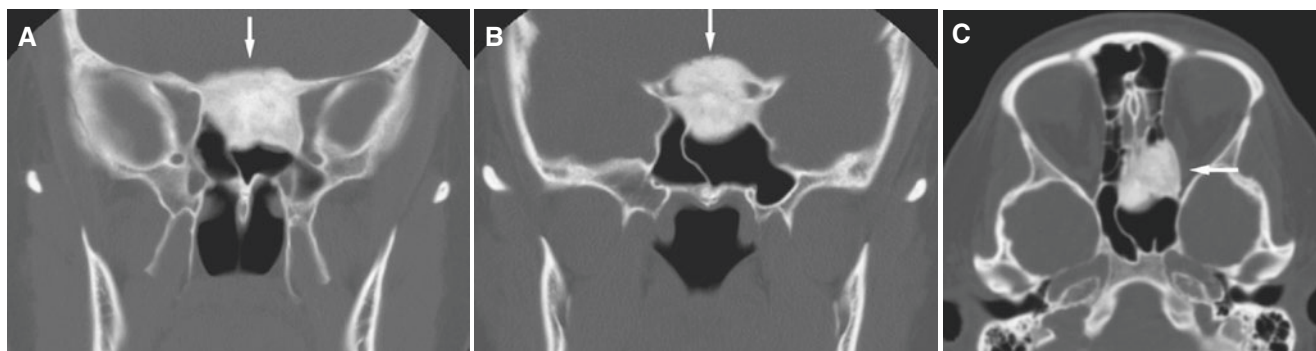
Sphenoid/ethmoid osteoma surgically confirmed, 24-year-old female with headache. (A) Coronal CT image shows well-defined dense mass in the sphenoid bone extending into sinus (*arrow*).
